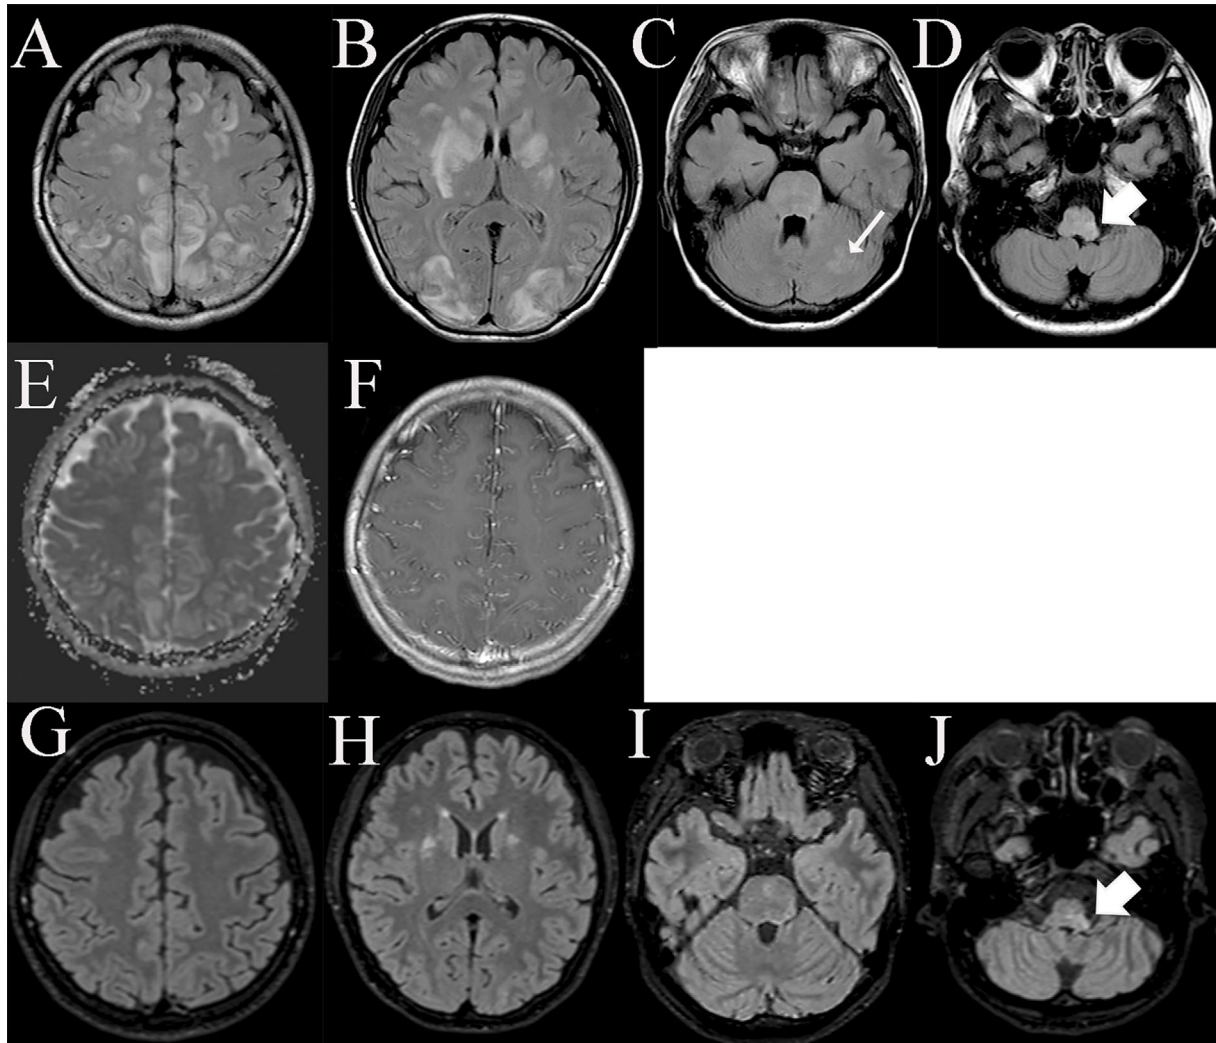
Brain MRI on admission (A-F) and after methylprednisolone pulse therapy (G-J). MRI shows symmetrical parieto-occipital, cortical, and subcortical lesions with a hyperintense signal on FLAIR (A) and on an apparent diffusion coefficient map (E), and these lesions are accompanied by leptomeningeal enhancement on postcontrast T1-weighted images (F). FLAIR images demonstrate hyperintense signal lesions in bilateral basal ganglia and occipital lobes (B), left cerebellar hemisphere (thin arrow, C), and left side of dorsal medulla oblongata (thick arrow, D). After methylprednisolone pulse therapy, the lesions in parieto-occipital lobes disappeared (G) and lesions in basal ganglia shrunk greatly (H). Left cerebellar hemisphere lesion also disappeared (I) but lesions in the dorsal medulla oblongata remained (thick arrow, J). MRI: magnetic resonance imaging, FLAIR: fluid attenuated inversion recovery
